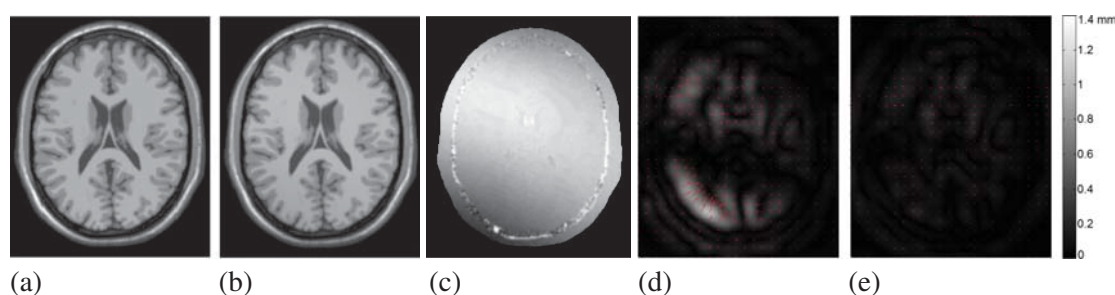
(a) T1-weighted brain image without an intensity non-uniformity field; (b) T1 image with an intensity non-uniformity field; (c) the non-uniformity field map; (d) the deformation field of registering (a) to (b) using normalised mutual information measure; (e) the deformation field of registering the two images using the proposed registration method. The error bar is the indicator for (d) and (e). A larger erroneous deformation is presented in (d) compared to (e). The error of (d) also follows the pattern of the bias field map in (c), while the registration error in (e) is evidently reduced. Brain MR data downloaded from BrainWeb.
